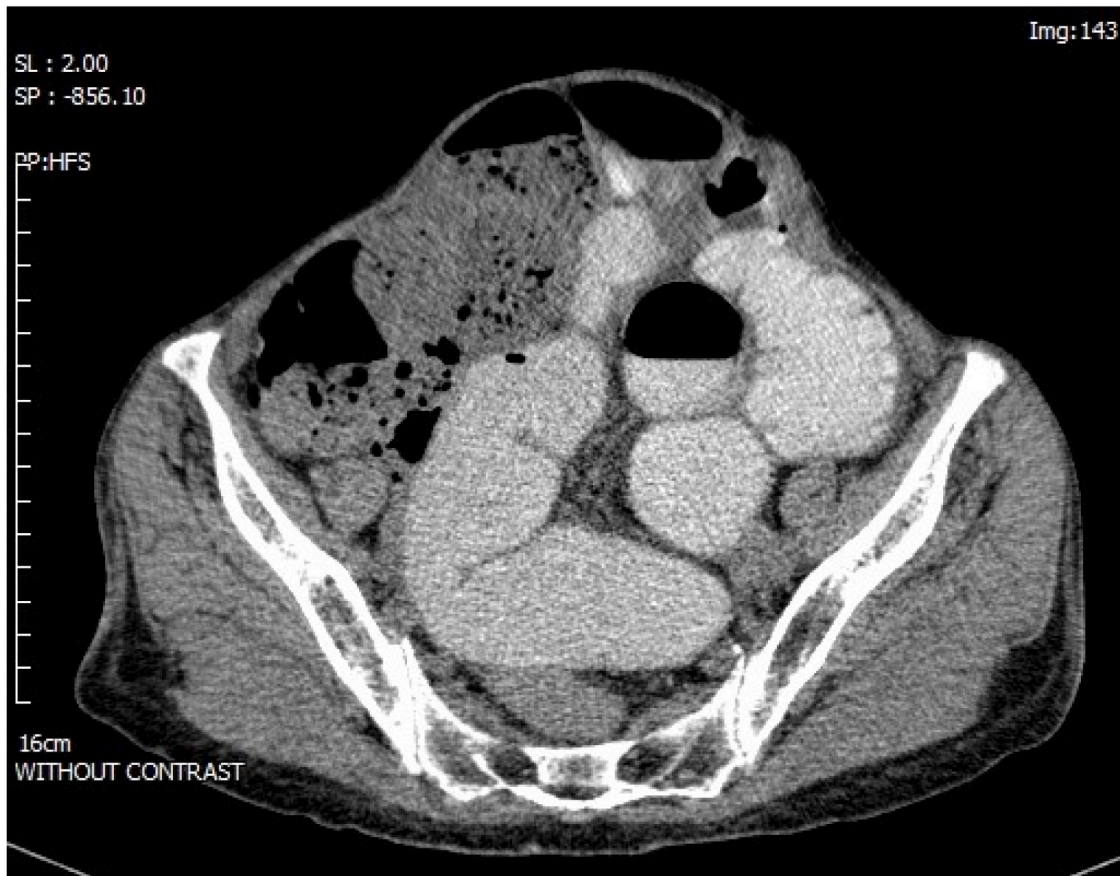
Pre-operative imaging; abdominal X-ray (A) & abdominopelvic CT scan (B).
